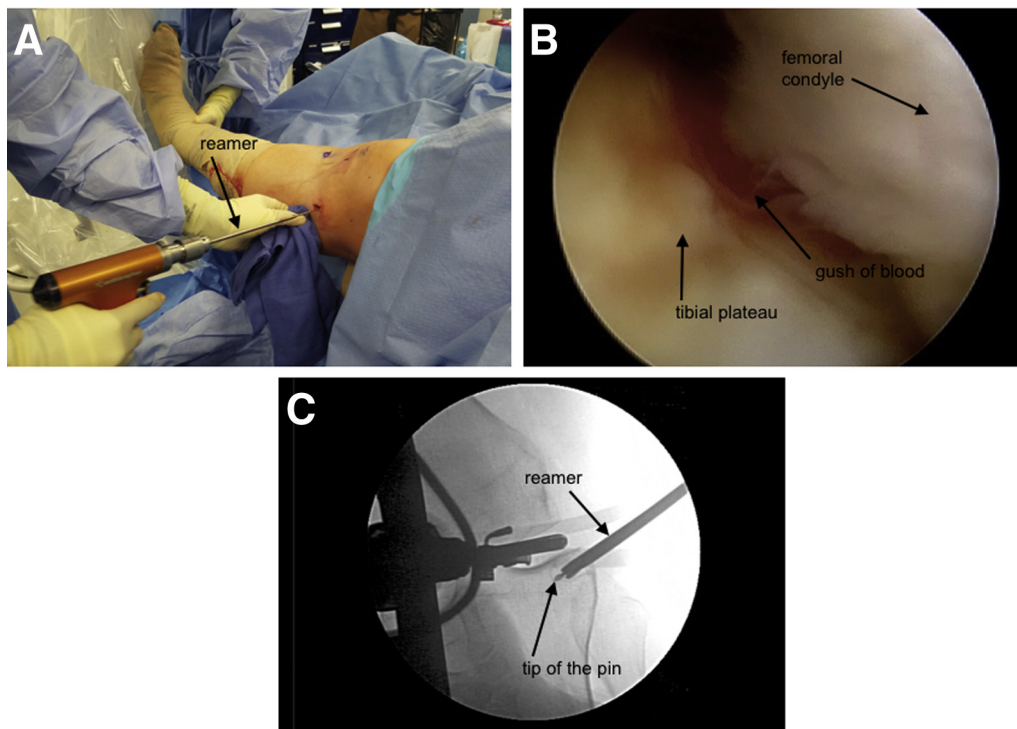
(A) A 5.5-mm reamer is about to ream the lesion and decompress the cystic area even further. It is necessary to avoid tibial plateau disruption during this step. If the lesion is located too close to the joint, this step must be skipped. (B) Arthroscopic picture of the left knee from the anterolateral portal. During the reaming process, it is advised to check the tibial plateau and ensure not to violate the cortex. The blood coming out of the reaming creates a bleeding bed that will trigger the healing process. (C) Radiograph of the left knee. It is possible to see both the pin the reamer on top. Fluoroscopic guidance will help avoid over-reaming the area.
